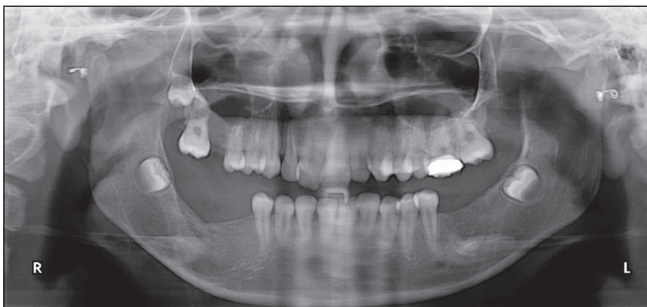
Postoperative orthopantomograph taken 7 months after surgery
